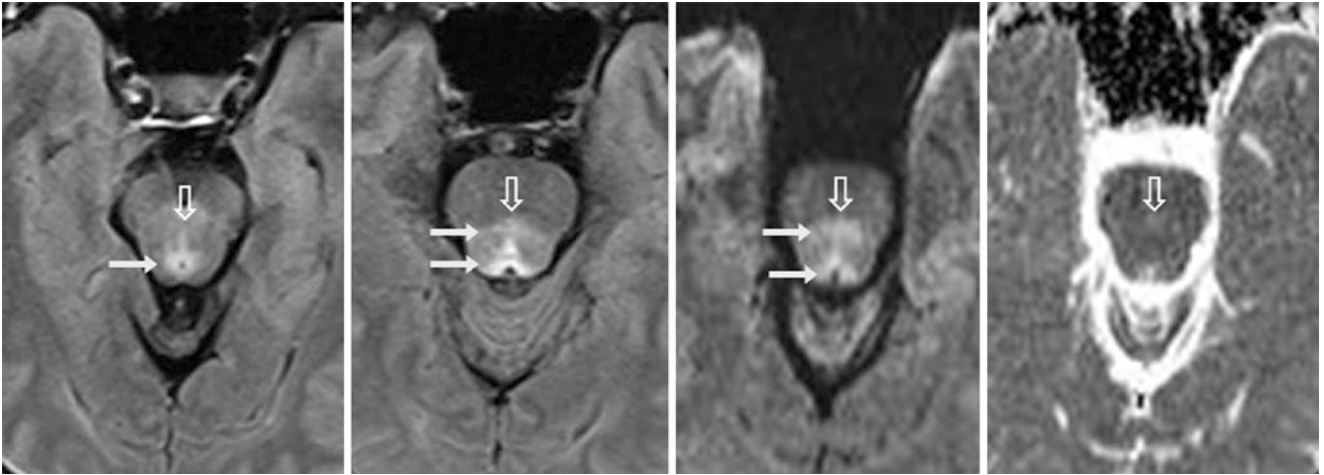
Comparison case of rhombencephalitis in a 54-year-old with cranial nerve III-IV palsy. Periaqueductal edema (*arrows*) was present on a 1.5 T MRI with FLAIR (*left and left middle*). At its anterior
